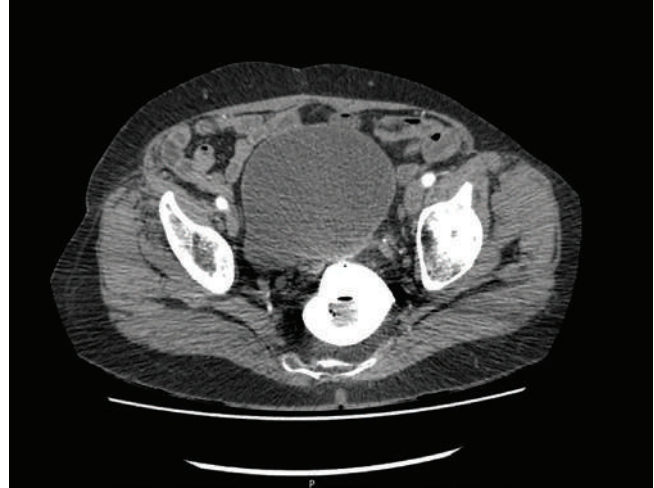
Radiographic appearance of a colorectal lesion on computed tomography.
